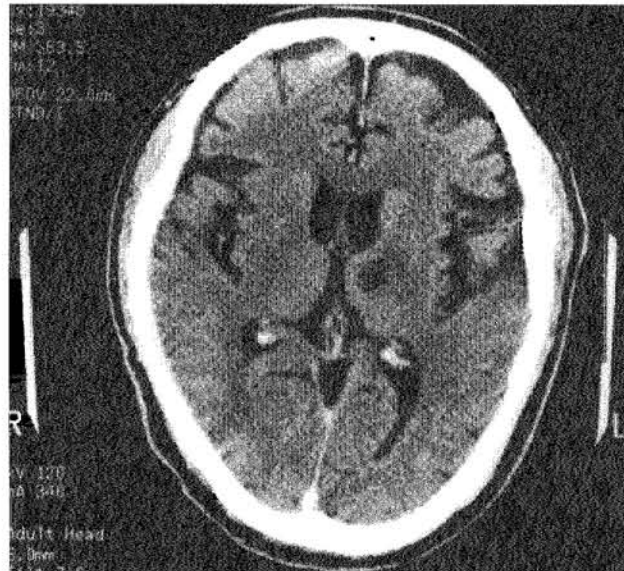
Post-operative axial CT image showing a left thalamotomy lesion
